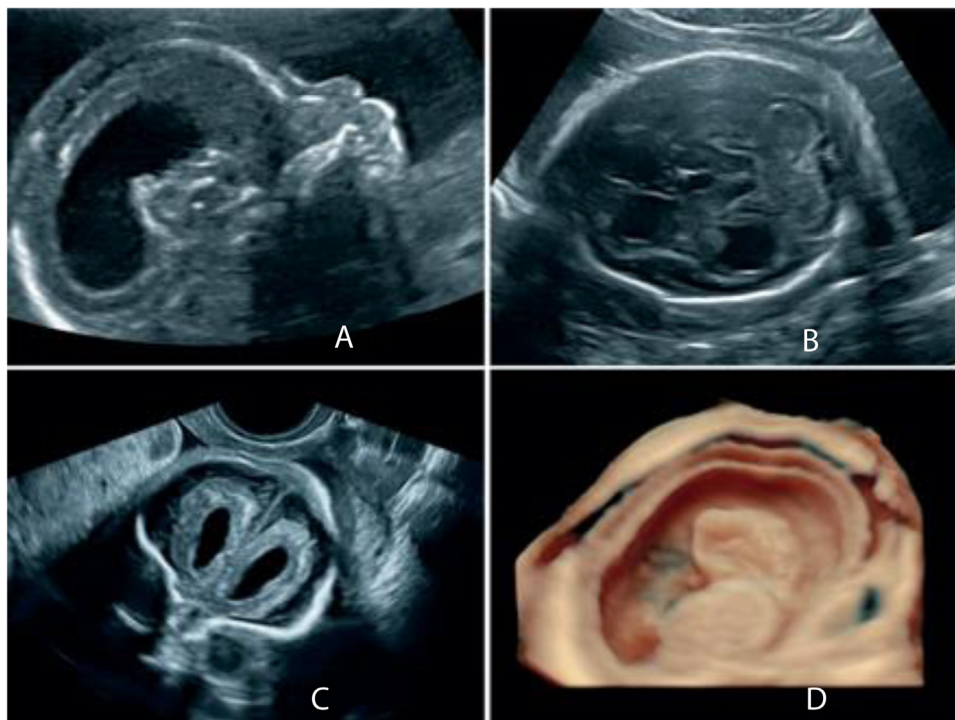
Congenital Zika virus infection showing Ventriculomegaly, atrophy of the cerebral mantle, and enlarged pericerebral spaces observed by abdominal and vaginal ultrasound at different times during gestation (A) Parasagittal view with ventriculomegaly at 19 weeks of gestation. 6B-Axial view at 28 weeks of gestation. 6C - Coronal view (frontal lobe) showing the atrophy of the cerebral mantle at 23 weeks of gestation (case G). 6D-3D reconstruction of a parasagittal view at 18 weeks of gestation. Moderate bilateral ventriculomegaly was sometimes associated with a prominent third ventricle. CM = cerebral mantle. V = ventriculomegaly. V3=third ventricle. X = pericerebral space. Courtesy of Schaub B et al. *Ultrasound imaging for identification of cerebral damage in congenital zika virus syndrome: a case series. Lancet Child Adolesc Health* 2017;1:45-55.
